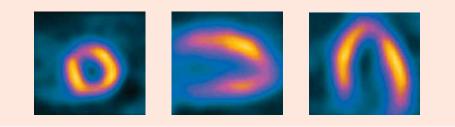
SAME-PATIENT COMPARISON OF SPECT MPI IMAGES OBTAINED DURING LEXISCAN AND ADENOSCAN STRESS
